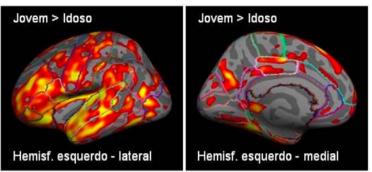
Reduced cortical thickness in normal aging. Areas in yellow and red show reduction in cortical thickness in elderly subjects (n = 10, mean age = 70 +/- 5 years) compared to young (n = 10, mean age = 27 +/- 12 years). Data collected with a 3T MRI.
